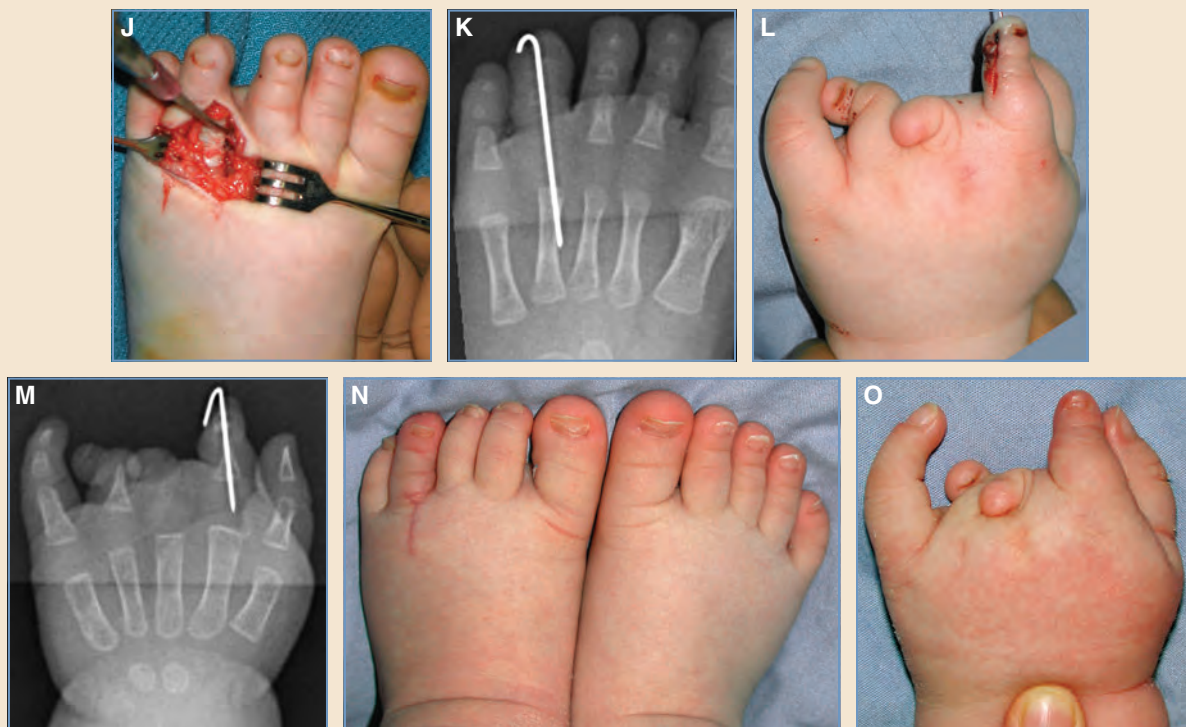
cont'd J, The iliac crest bone graft is adjusted to fit the toe phalanx donor site, and is pinned with a longitudinal K-wire before the wound is closed. K, Anteroposterior radiograph of the left foot after iliac crest bone grafting of the toe phalanx donor site. L, Appearance of the index finger after transfixion pinning of the reduced toe phalanx into the distal soft tissue sleeve. Chondrodesis between the distal end of the index proximal phalanx and base of the toe phalanx was undertaken, as was suturing of the toe phalanx ligament to the perichondrium on the radial side of the index proximal phalanx. There was not enough space to do the same on the ulnar side. M, Posteroanterior radiograph of the left hand with the pinned toe phalanx in place at the distal end of the index finger. N, Left foot 2 months after surgery. No toe shortening, instability, or stiffness is present at the metatarsophalangeal joint at 2 months or 6½ months after surgery. O, Left hand 2 months after surgery. Stability is improved in the previously flail index fingertip and is now used in pinch.
